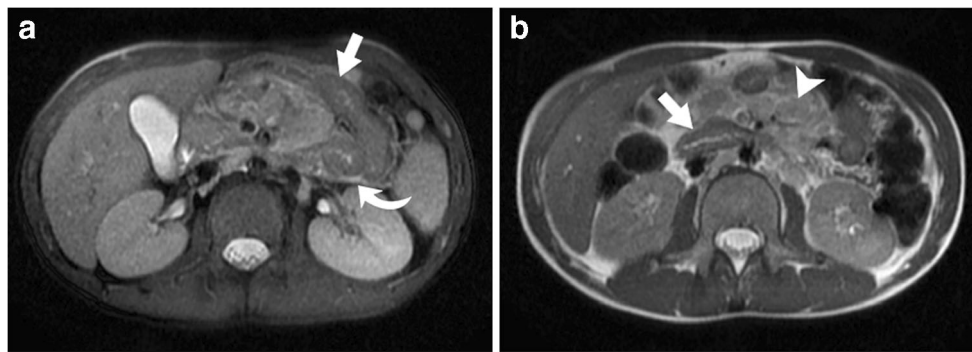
Tumor necrosis factor receptor-associated periodic syndrome (TRAPS) in an 11-year-old boy with fever, abdominal and musculoskeletal pain. Axial fat-suppressed T2-weighted (a) and axial T2-weighted MRI (b) of the abdomen show segments of small bowel wall thickening (straight arrows), mesenteric and retroperitoneal lymphadenopathy
